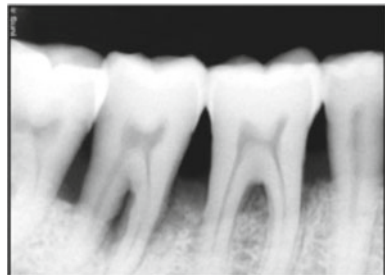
Preoperative radiograph at baseline
